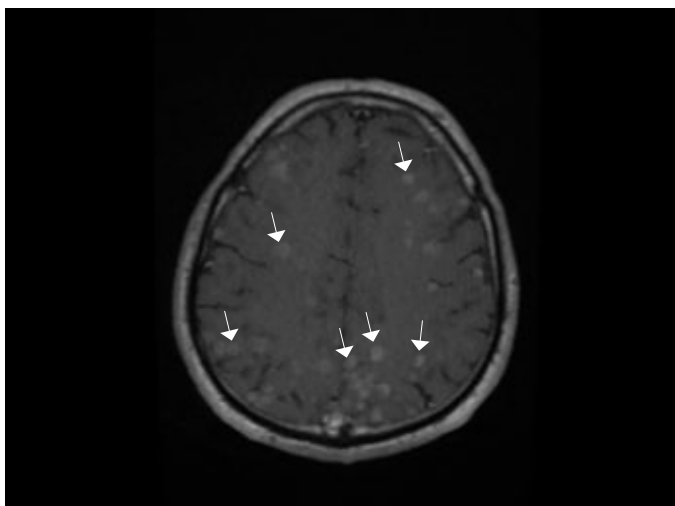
Intravenous contrast-enhanced cranial magnetic resonance imaging of the patient showed transverse plane (white arrows)
